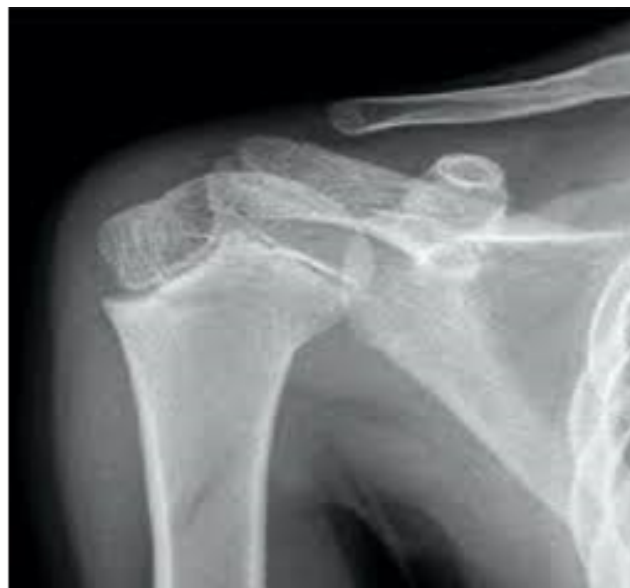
X-ray Shoulder joint - unfused
